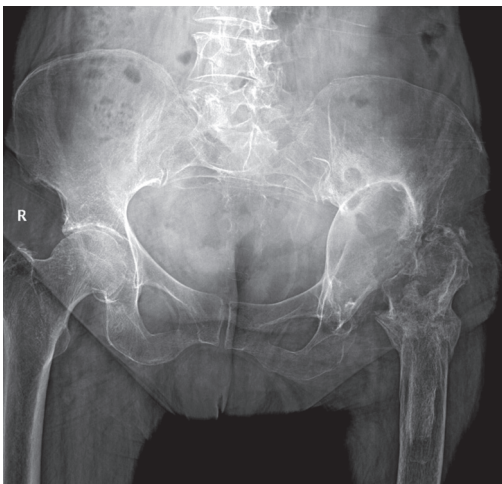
X-ray of female patient 62 y.o.: post-implantation Paprosky IIIB defect of the left acetabulum.
